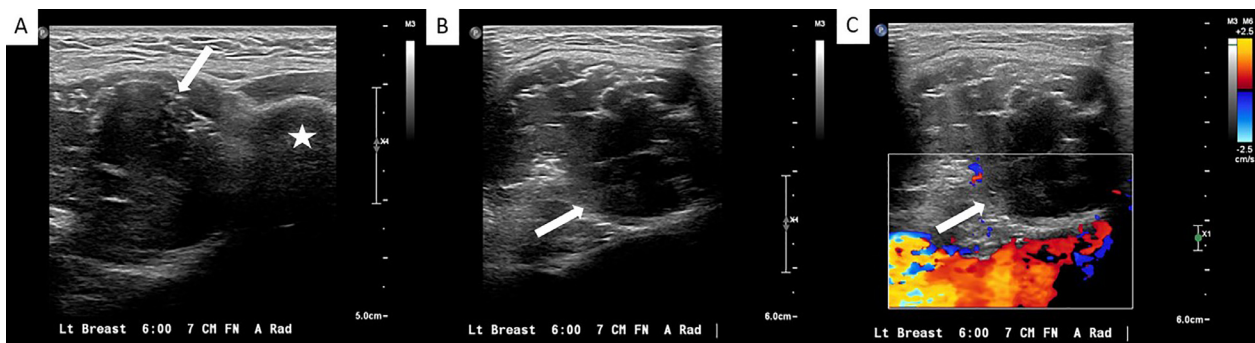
Further US examination of the mass (white arrows) revealed its proximity to an anterior rib (white star, A) as well as an anechoic cardiac chamber just deep to it without intervening chest wall musculature (B), with confirmatory color filling of the cardiac chamber with Doppler (C).
